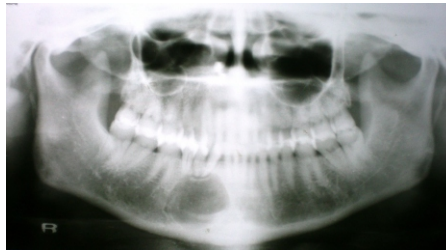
Panoramic radiograph showing unicystic radiolucent lesion in the lower right jaw in relation to premolars with a clear demarcation
